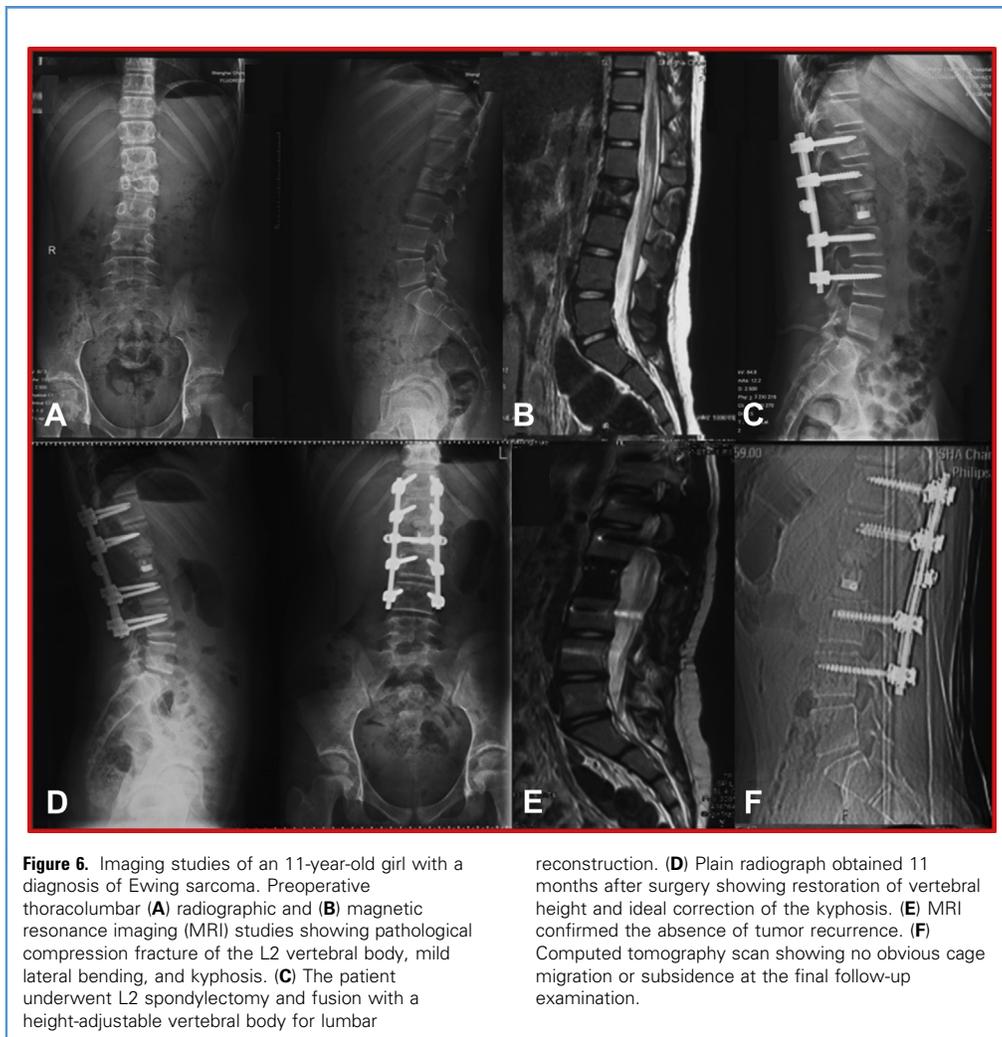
Imaging studies of an 11-year-old girl with a diagnosis of Ewing sarcoma. Preoperative thoracolumbar (A) radiographic and (B) magnetic resonance imaging (MRI) studies showing pathological compression fracture of the L2 vertebral body, mild lateral bending, and kyphosis. (C) The patient underwent L2 spondylectomy and fusion with a height-adjustable vertebral body for lumbar
